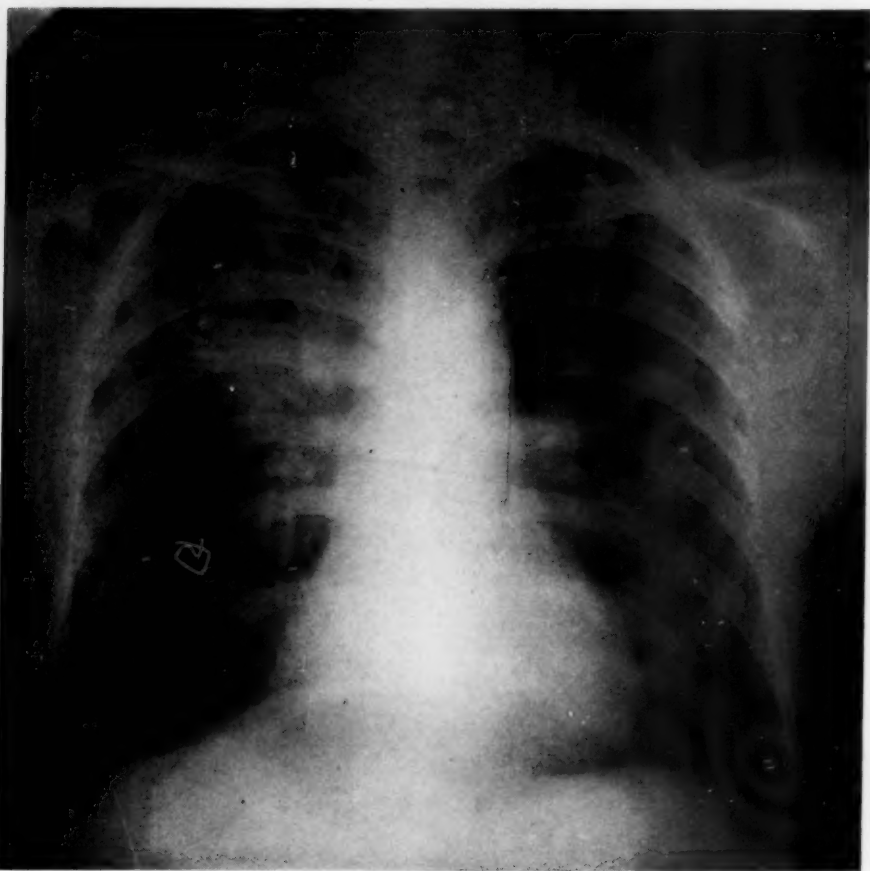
(Case 4.) Roentgenogram taken July 2, 1940. Infiltration in the right upper lobe with an area of rarefaction suggestive of cavitation at the level of the second anterior rib.
